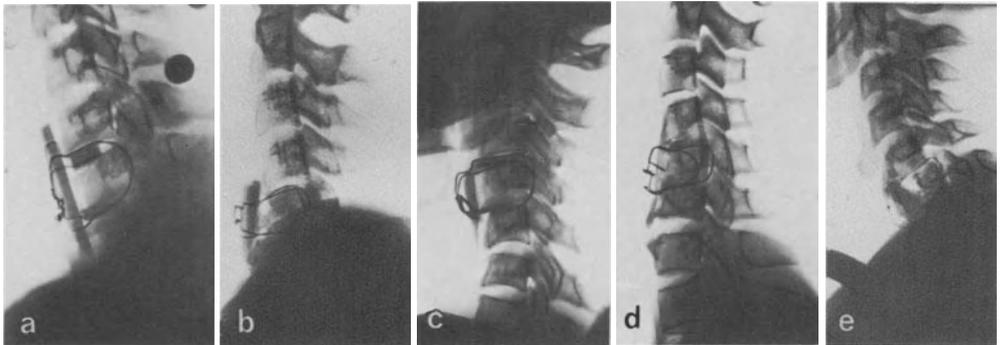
a-d. The radiographs after internal fixation of compression fractures; preoperative status (see Fig. 5). a 2 days after operation; b 1 month after operation; c 12 months after operation; d 2,5 years after partial replacement of vertebral body + internal fixation. Note: The radiographs reveal depending upon the time after operation the partial or complete resorption of bone-grafts
